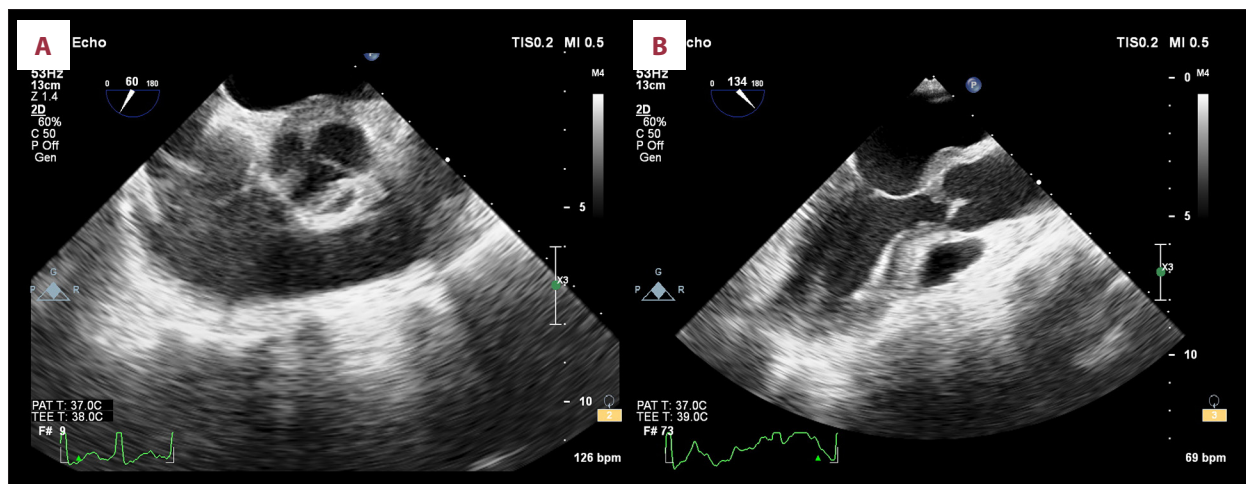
(A, B) Echocardiographic features of the patient, which were mistakenly identified as SBE.
